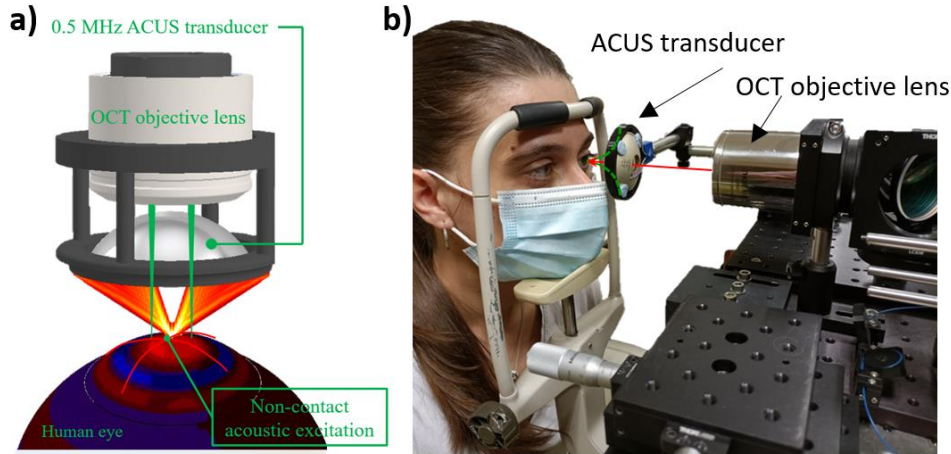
Ultrasonic excitation module setup. In (a), the 500 kHz ultrasonic air-coupled transducer is co-focused with the sample arm of the swept-source OCT system reported in [13] in order to produce Lamb wave propagation in the cornea. In (b), the real distribution of the ultrasonic transducer, OCT objective lens with respect to the patient cornea is shown.
